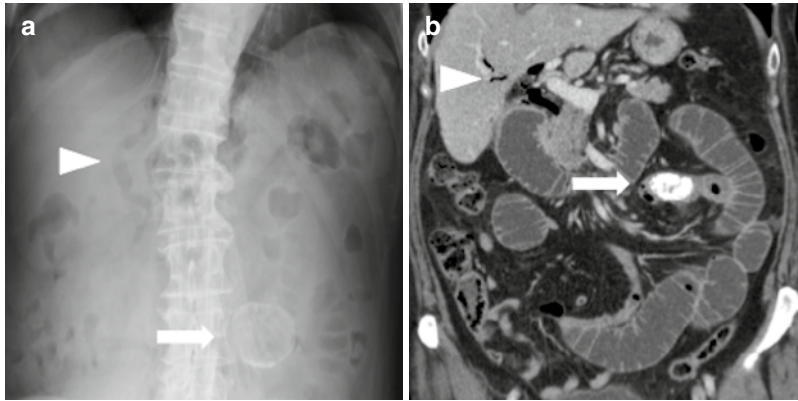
Supine abdominal X-ray (A-XR) and contrast-enhanced computed tomography (CECT) in gallstone ileus with atypical localization of the impacted stone. (a): A calcified round gallstone is projected over the left flank (arrow) in combination with air seen in the biliary tree—
